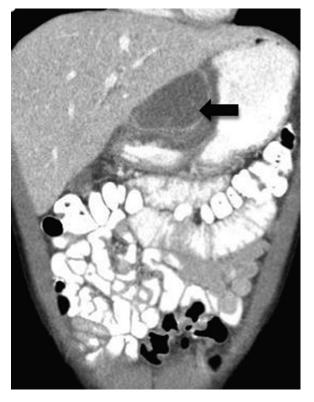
Coronal CT image through mid-abdomen shows an oval mass between the contrast-filled stomach and left lobe of liver.
